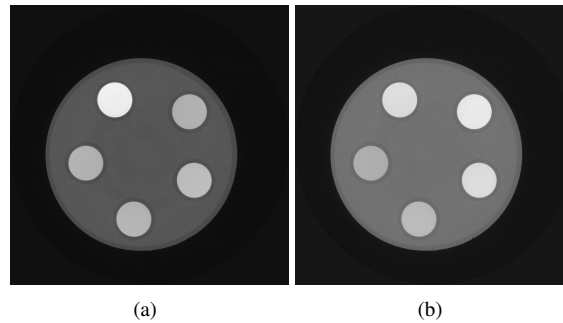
Reconstructed CT slice of the scans performed at 100 kV using 0.1 mm W (a) and at 180 kV using 1 mm Cu (b)
